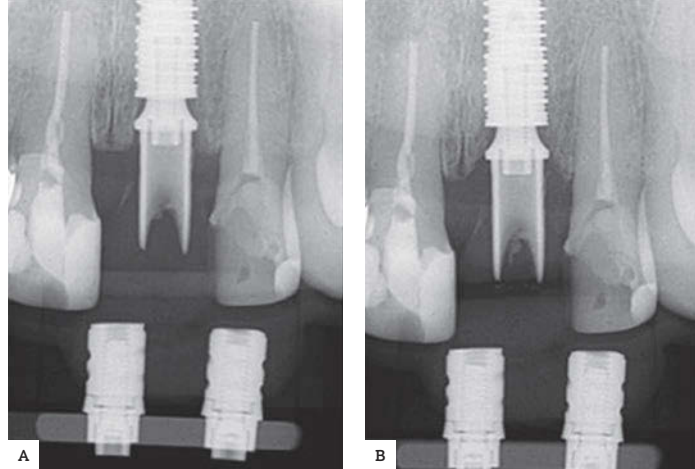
A) Radiograph taken at baseline. B) Radiograph taken at 6-month follow-up. Note the good standardization of geometric positioning.
